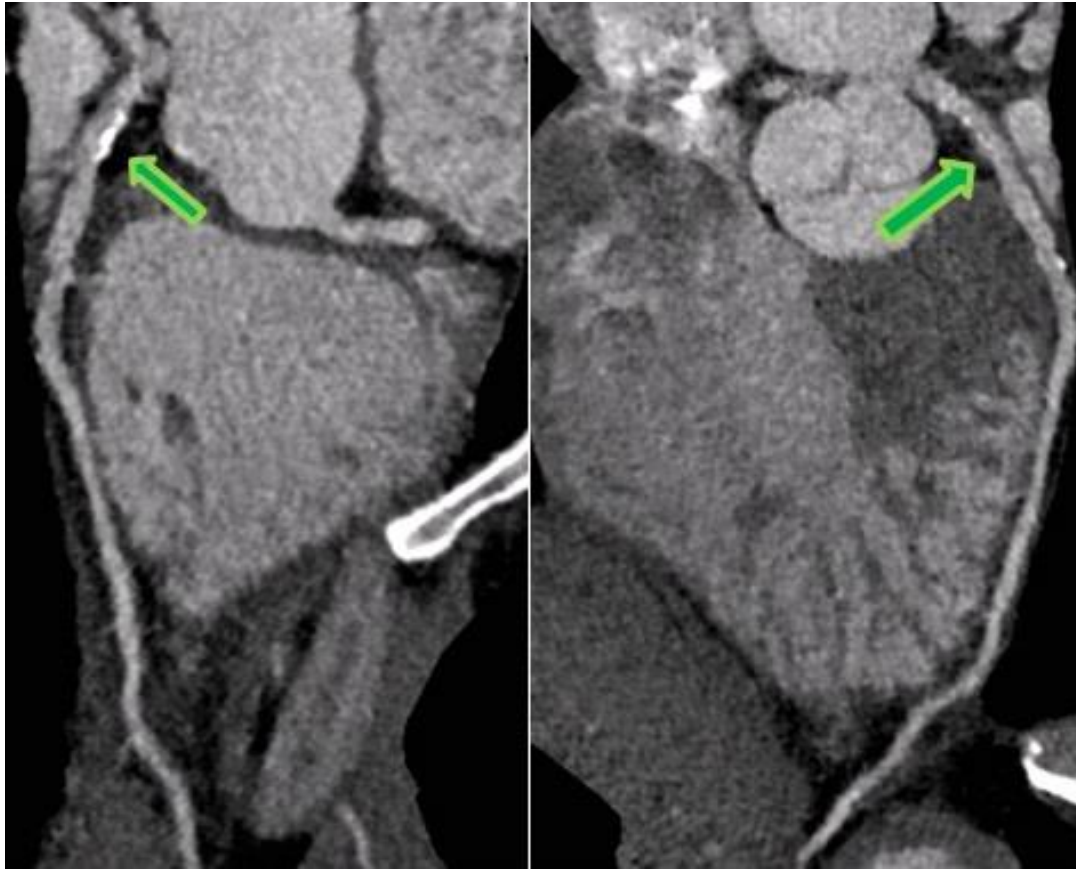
Mild diffuse coronary atheroma with moderate coronary calcification (Agatston score: 112) on CT coronary angiogram in an asymptomatic patient with stage 3 CKD.
